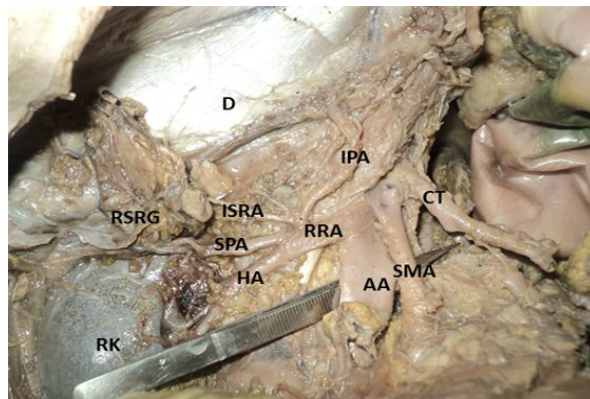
Showing variation of origin of Inferior Phrenic artery from the right renal artery. (D- Diaphragm, RSRG- right suprarenal gland, ISRA- Inferior suprarenal artery, SPA- Superior polar artery, HA- Hilar artery, RK- Right kidney, RRA- Right renal artery, AA- Abdominal aorta, SMA- Superior mesenteric artery, CT- Coeliac trunk, IPA- Inferior phrenic artery.)
